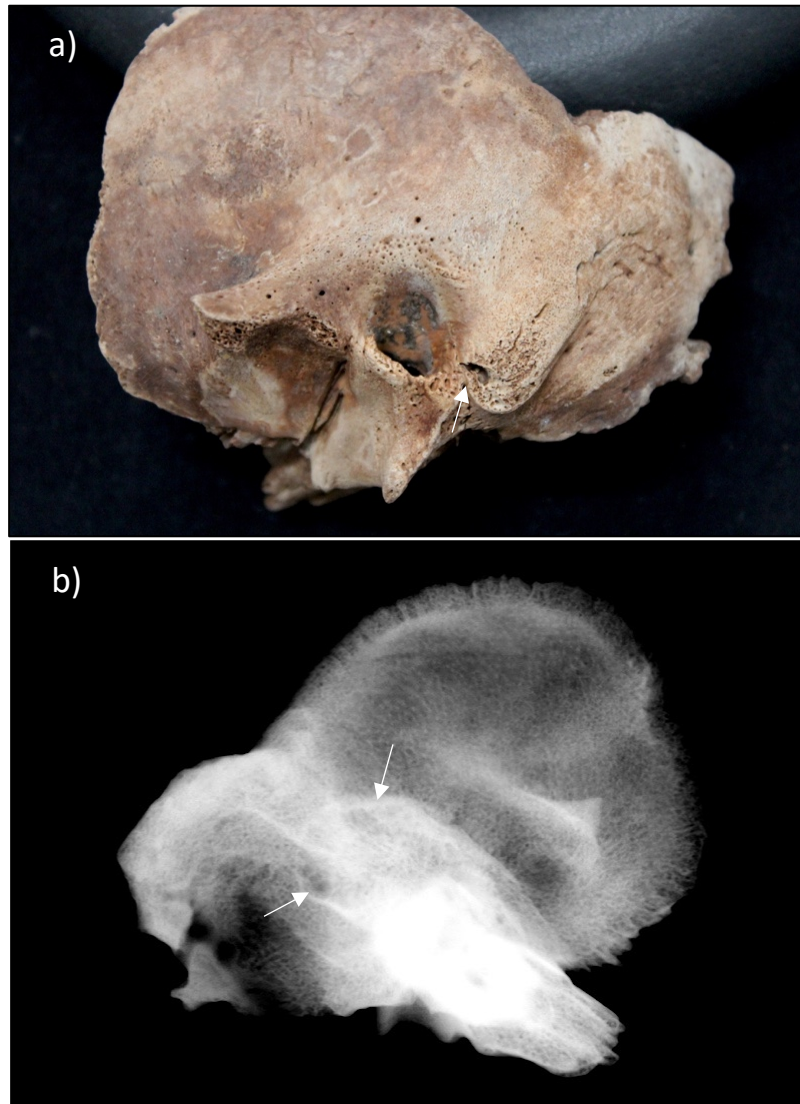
Mastoiditis in a child (Edo period Japan, Temporal Bone). a) Small focal osteolytic lesion on the external aspect of the mastoid (white arrow). b) The radiographs demonstrate considerable internal lytic destruction (white arrows). Image: author's own
